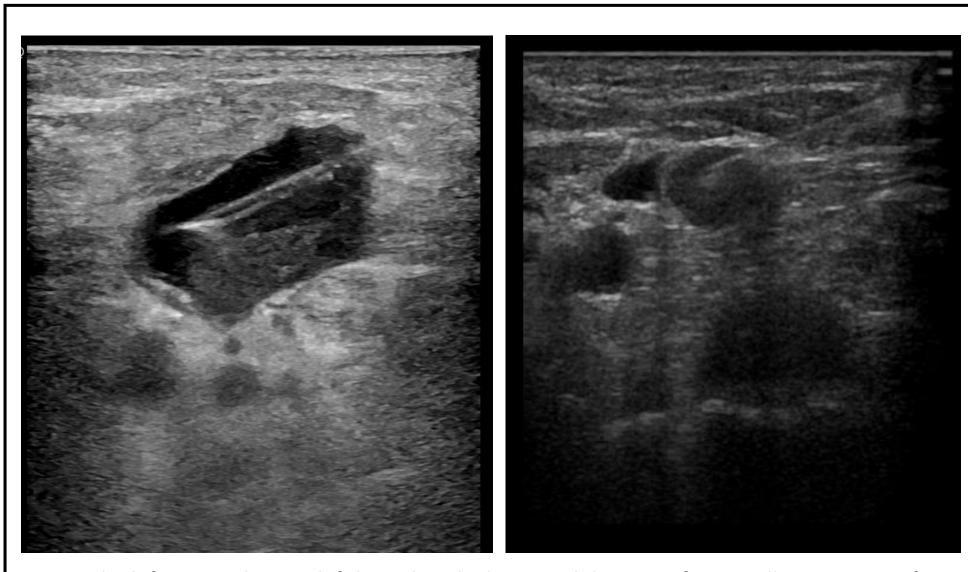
The left image shows a left lateral neck ultrasound depicting fine needle aspiration of a cervical lymph node with a 20-gauge needle. The right image also shows a left lateral neck ultrasound depicting fine needle aspiration of a cervical lymph node, though with an 18-gauge needle.
